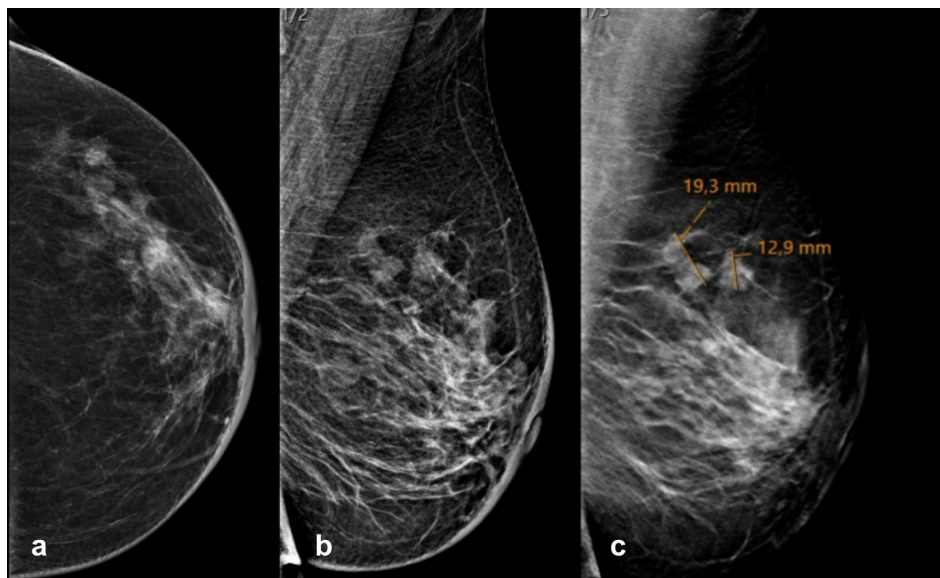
A 39-year-old woman presented with a palpable hardness in her left breast. A diagnostic MMG scan performed for a preliminary diagnosis of malignancy revealed adjacent millimetric nodular opacities with unclear contours in the upper outer quadrant of her left breast. The DBT image revealed two lesions with irregular contours (BI-RADS 4C). (Ultrasound assessed the lesions as highly suspicious for malignancy, and the biopsy result was reported as invasive ductal carcinoma, grade 3, Estrogen Receptor: 90%, Progesterone Receptor: 60%, and Ki-67 index: 20%). MMG, Mammography; DBT, Tomosynthesis; BI-RADS, Breast Imaging Reporting and Data System.
